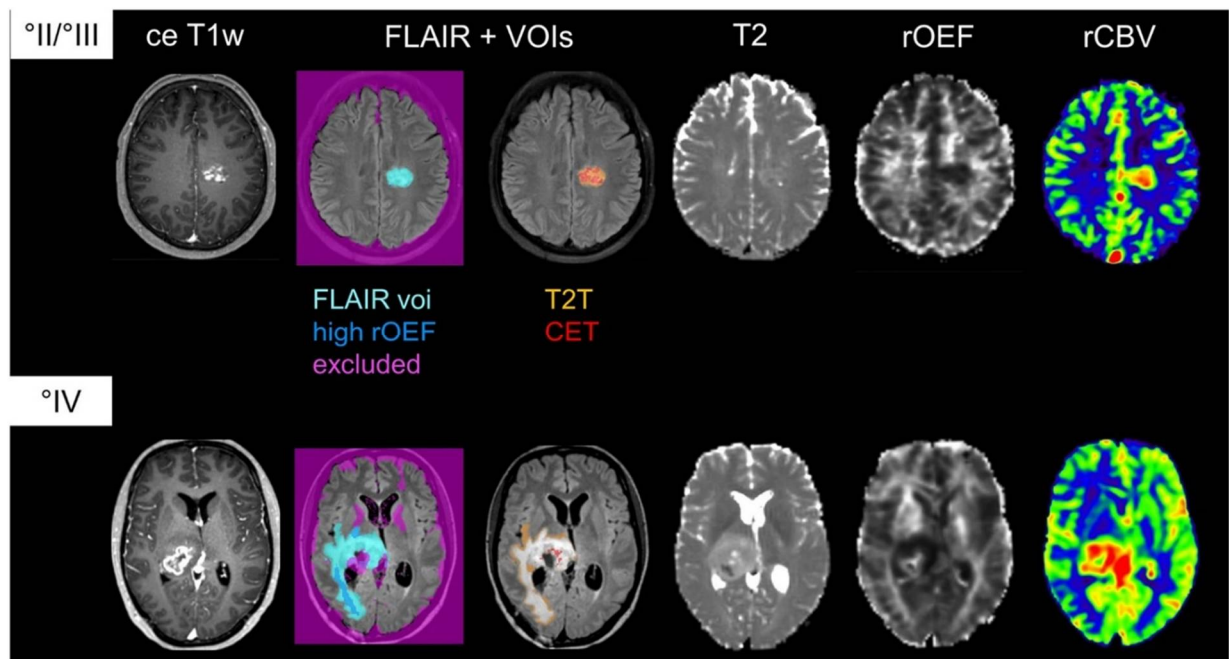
Multiparametric MRI-based differentiation of WHO grade II/III gliomas and WHO grade IV. [D]
